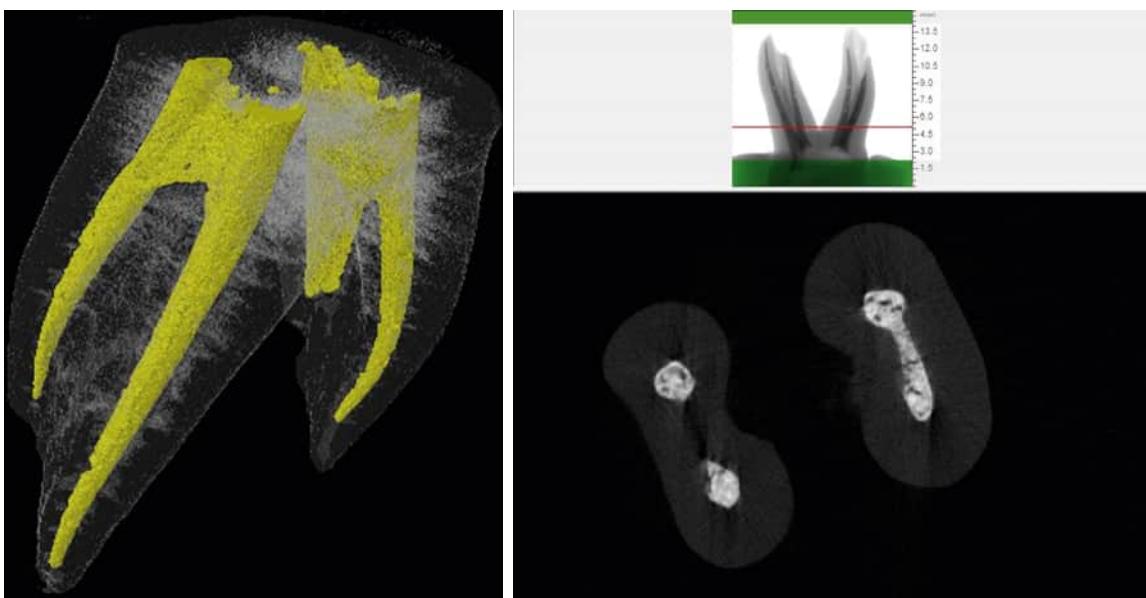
Three views of micro-computed tomographs of a mandibular second primary molar root canal system obturated with Vitapex. (Courtesy of Dr. Ashraf Al-Hosainy, Mansoura University School of Dentistry, Egypt.)
